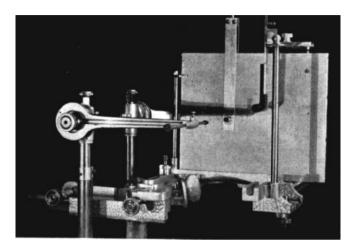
The Head Holder with cassette in its place for lateral roentgenogram.
